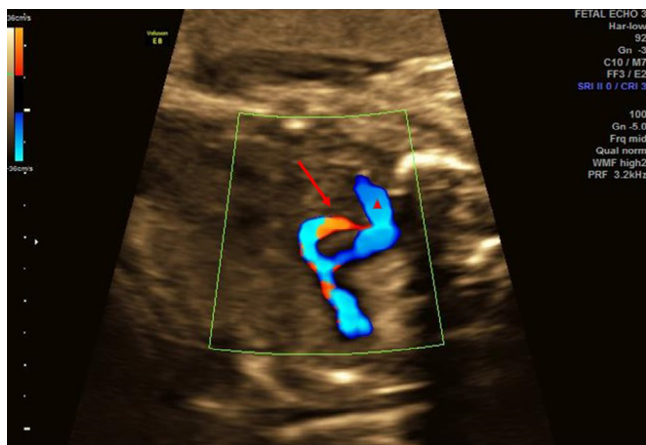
Fetal echocardiogram at 28 weeks and 4 days' gestation demonstrates an aberrant vessel with the appearance of a pulmonary sling. The arrowhead marks the main pulmonary artery, whereas the arrow marks the aberrant vessel, presumed to be the left pulmonary artery originating from the right pulmonary artery.
